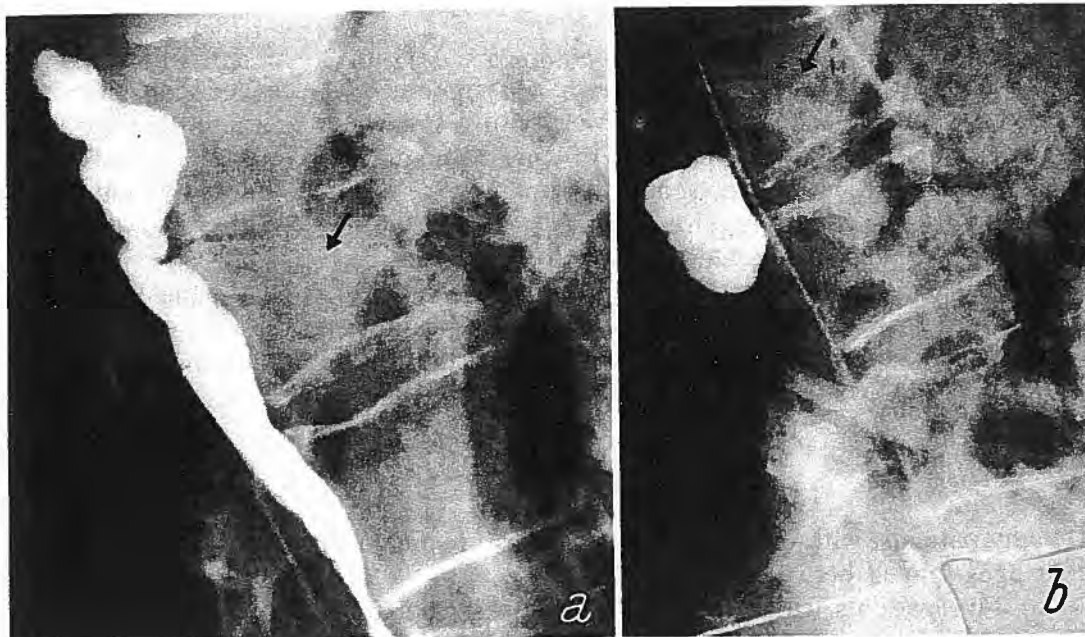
a A lateral radiograph of the lumbar spine of a male patient aged 58 years. Note the preservation of the disc spaces and there is no evidence of degenerative spondylosis. *The pedicles of L3 and L4 appear short.* b A lateral radiograph of the same spine showing a myelogram with complete spindling and obstruction of the column at the L3/4 level. This appearance is typical of spinal canal stenosis at a single level
